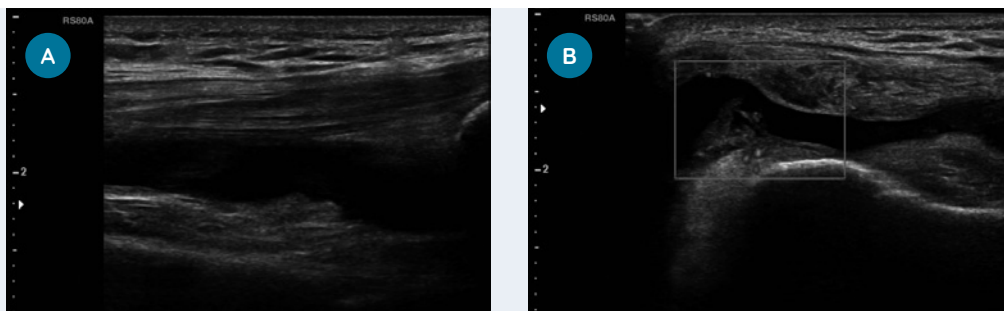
Male patient, 71 years old. Right gonalgia. Ultrasound image showing joint effusion (notable anechoic distension of the suprapatellar recess in both the longitudinal axis image, section A, and the transverse axis image, section B) and synovial hypertrophy with a pattern of mild hypervascularization on power Doppler examination (documented in the transverse axis image, section B). Analysis of the synovial fluid, which revealed the presence of calcium pyrophosphate crystals, combined with a thorough radiographic examination of the knee, which detected meniscal calcifications and calcifications at the femoropatellar joint, led to the diagnosis of co-occurring gonarthrosis and calcium pyrophosphate arthritis
